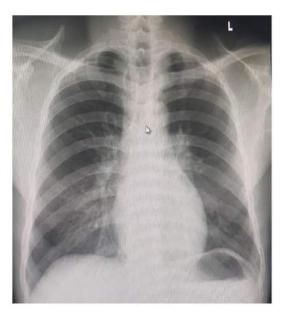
Chest X-ray of the patient (normal finding with no evidence of tuberculosis)
